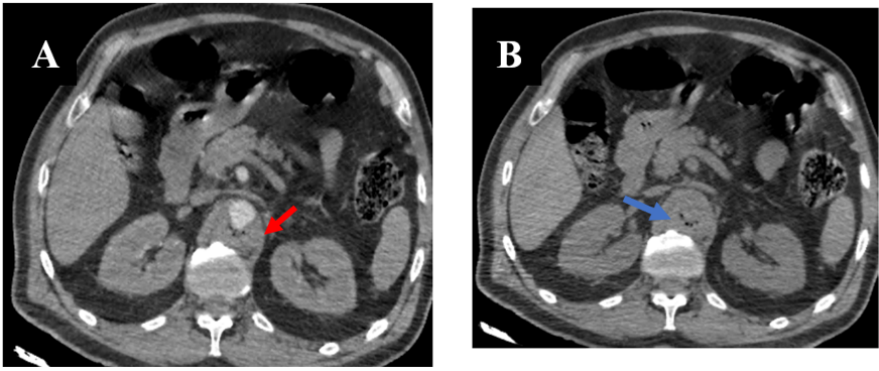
Axial abdominal CT images.
